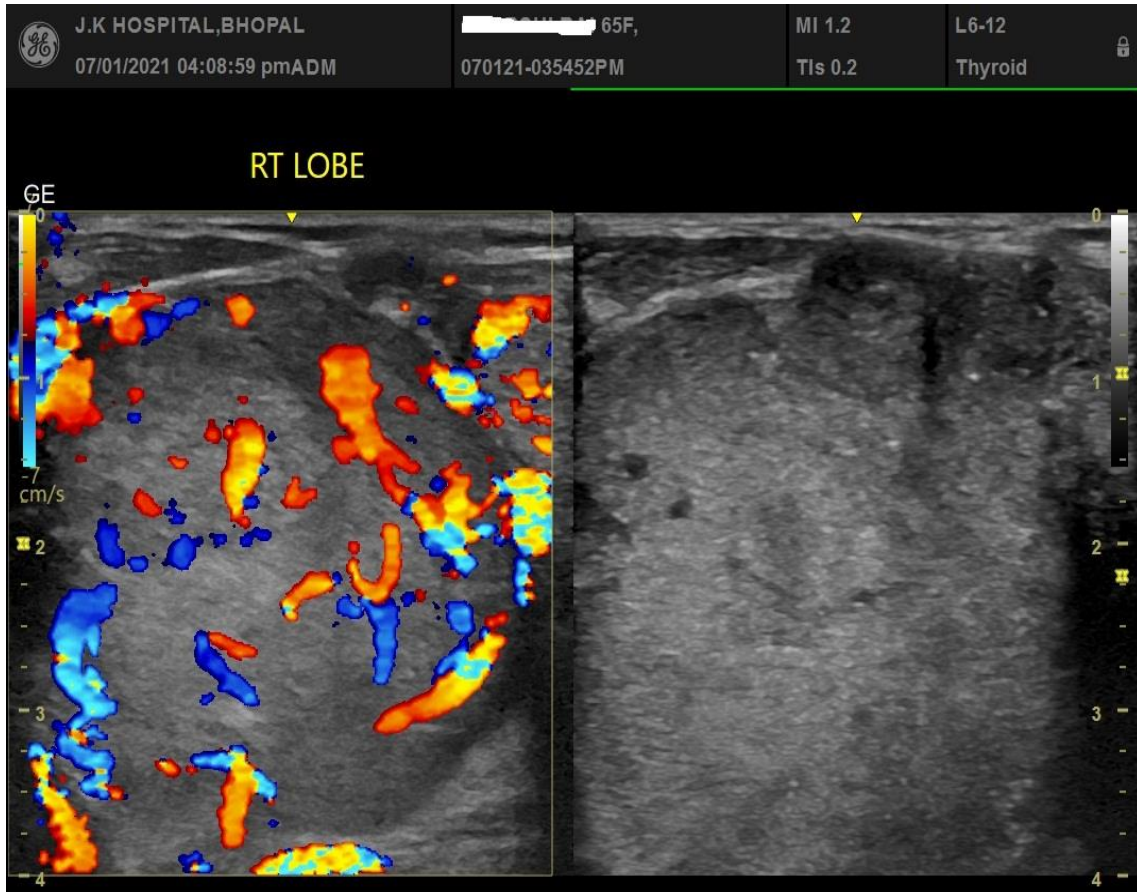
Follicular Carcinoma-Gray scale HRSG showing hypo to isoechoic, solid, irregular margins, taller than wider lesion in right lobe of thyroid (b)Doppler USG shows increased internal vascularity.
